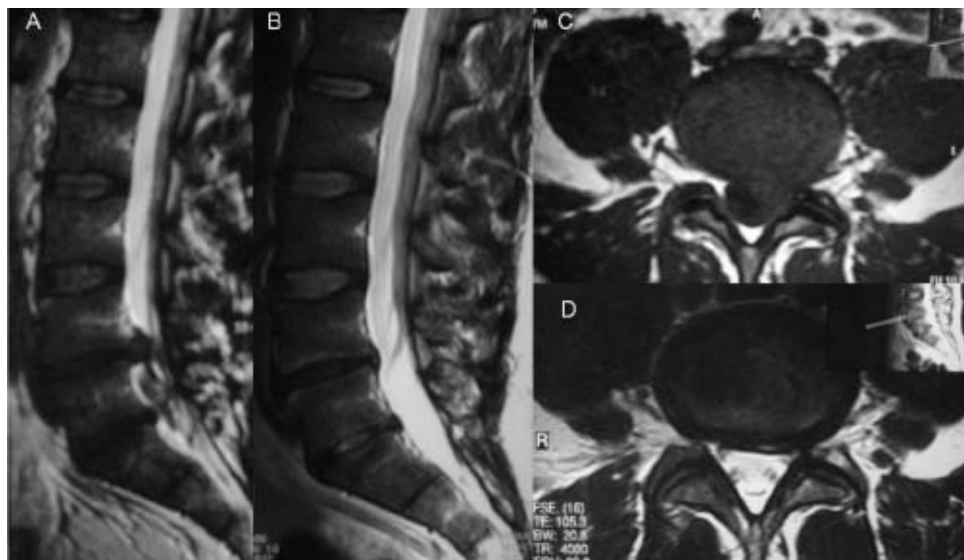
A 32-year-old man with L5 left radiculopathy caused by a great disc herniation (A and C). Both in axial and sagittal MR images (T2-weighted) disc is “extruded” in spinal canal and the material press left L5 root. After 6 months in the same patient, treated with O_2 - O_3 injections, MR shows strong reduction of herniated disc clear both in axial and sagittal images (B and D).
